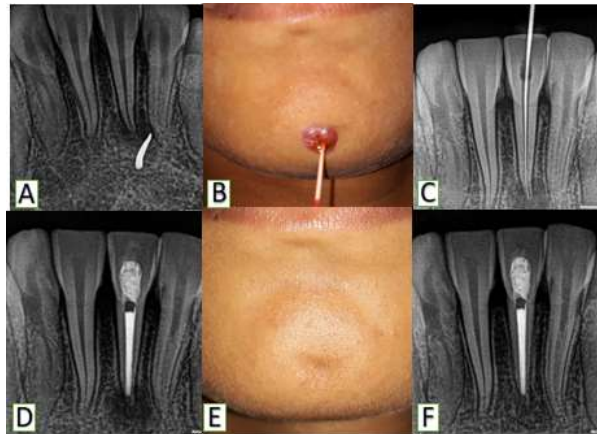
(A) (B)Pre-operative radiograph and clinical photograph showing extra oral sinus being traced with gutta percha (C) working length determination (D) post obturation radiograph (E) Follow up at 6 months with healed extra oral sinus. (F) Radiograph at 6 months follow up.
